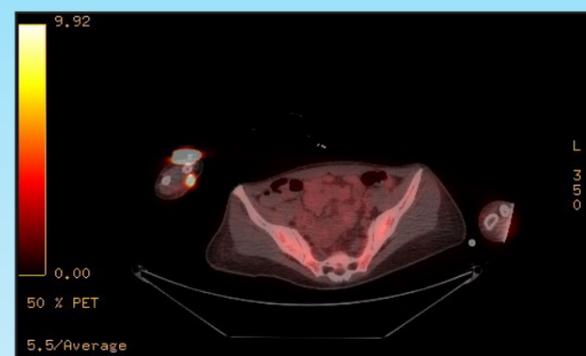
Pelvic PET-CT showing diffuse FDG uptake in the axial skeleton and pelvis, which was considered reactive in nature, but normal pelvic viscera.
